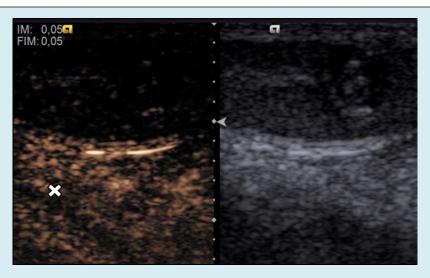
Contrast enhanced ultrasound. No contrast enhancement (cross) identified in either of two lesions.
